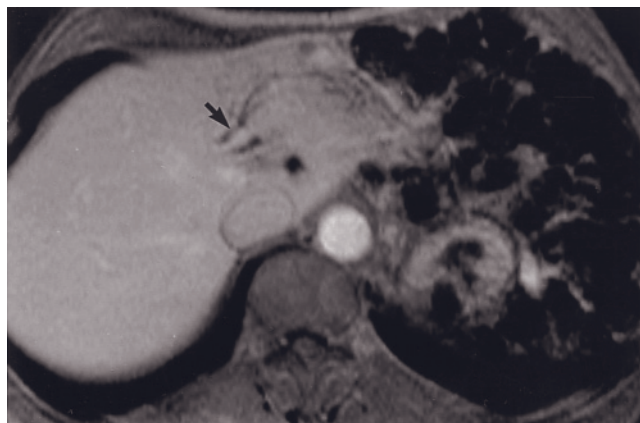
Biliary tree air. Transverse 90-s postgadolinium SGE image in a patient with a choledochojejunostomy shows signal-void, tubular structures with an arborized pattern (arrow). This biliary tree air is more central in location than the portal venous air. The T2-weighted image (not shown) demonstrates signal-void, poorly shown bile ducts consistent with air-containing rather than fluid-containing ducts.
